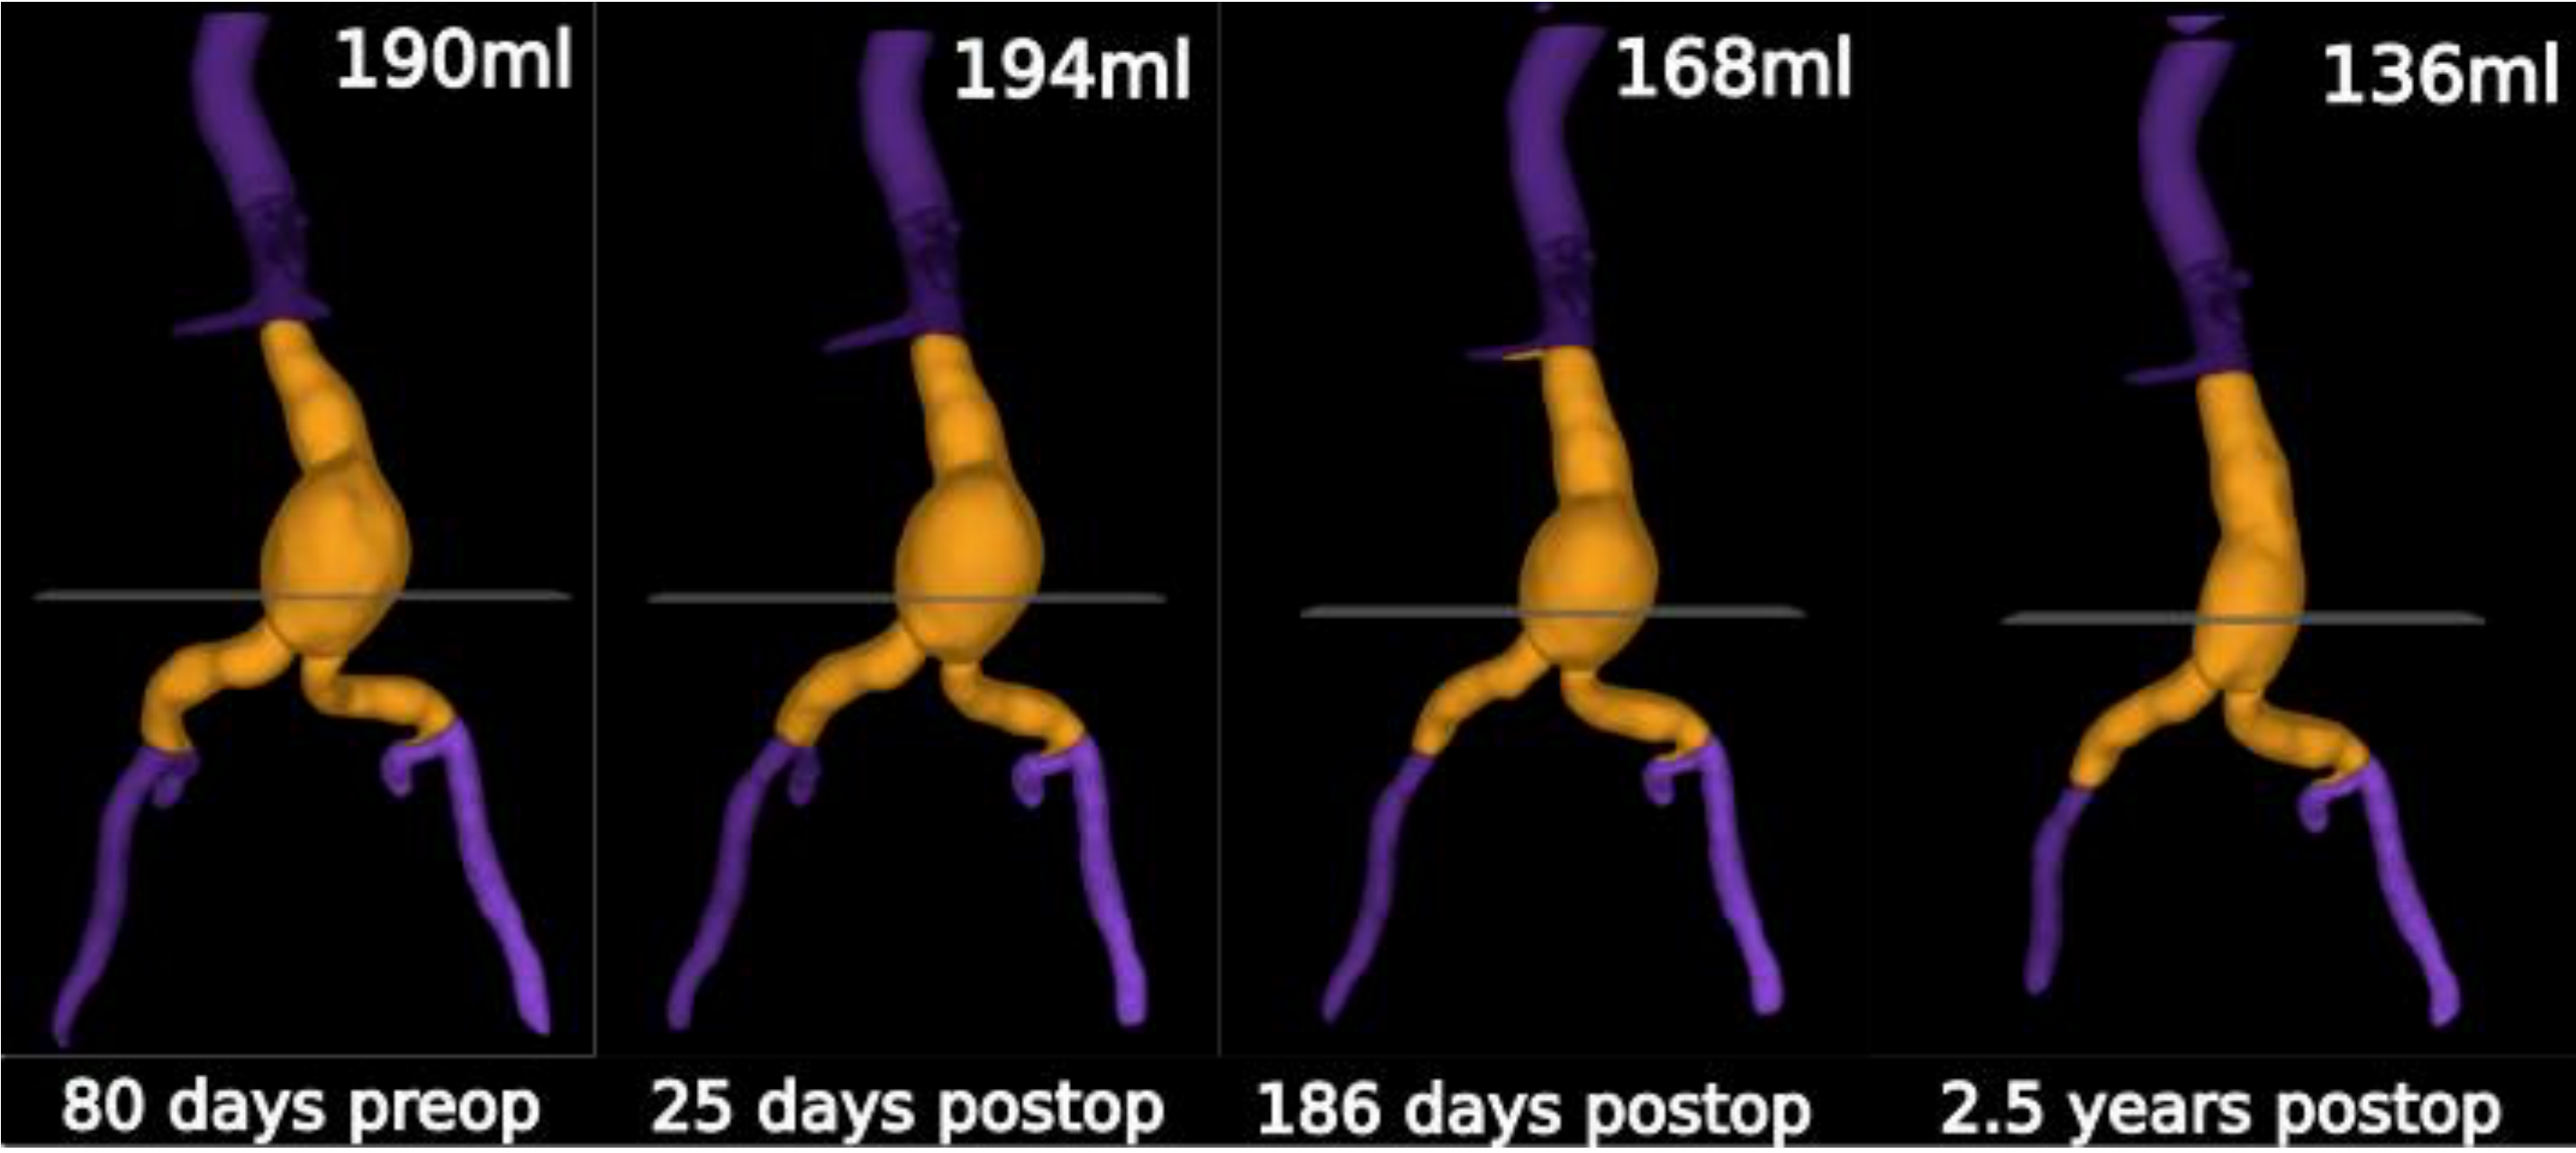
Series of surface renderings from preoperative CT scan (far left) and three follow up scans. Segmentations show decrease in aortic volume after successful aneurysm repair.
